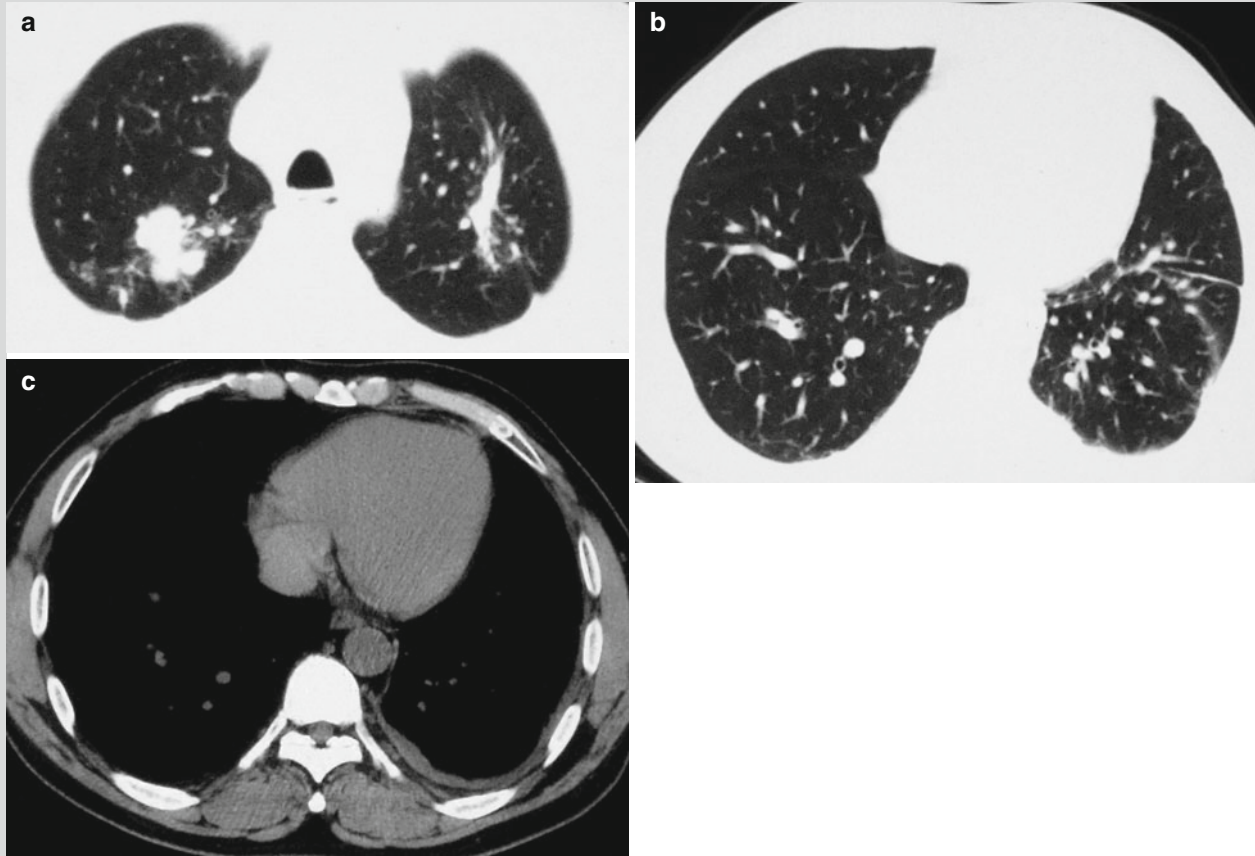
Infiltrative pulmonary tuberculosis and dry pleuritis. (a) CT scanning demonstrates spots and patches of shadows at the posterior segment of the right upper lung lobe. (b) CT scanning demonstrates cord-like shadow at the apical posterior
